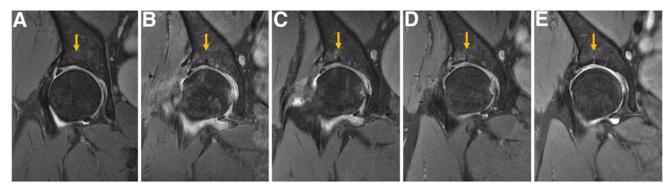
Pre- and postoperative magnetic resonance images of acetabular cartilage delamination in right hip of 53-year-old female patient in the oblique coronal plane. The yellow arrows point to the site of chondral nail. (A) Preoperation, (B) 3 months after operation, (C) 5 months after operation, (D) 7 months after operation, and (E) 23 months after operation. The nail is gradually absorbed in place without displacement or foreign body reaction.
